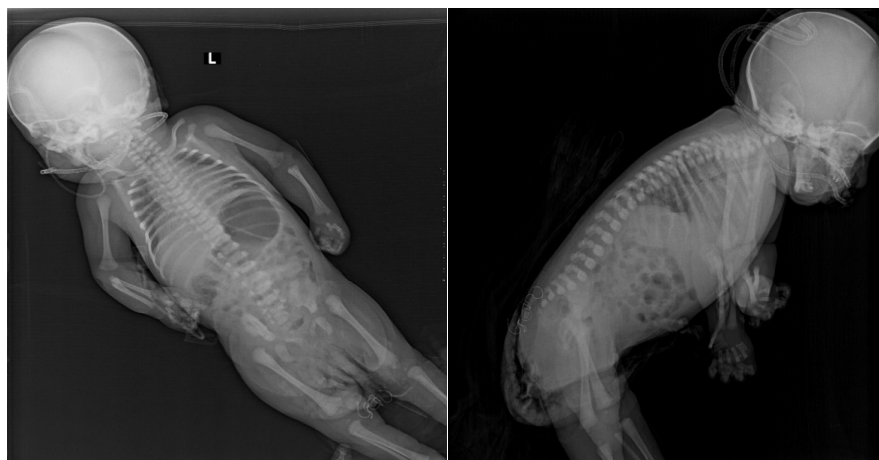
Skeletal survey images of the index patient. The right paracardiac opacity seen on the chest radiograph/scout image corresponds to the dome of the liver.
